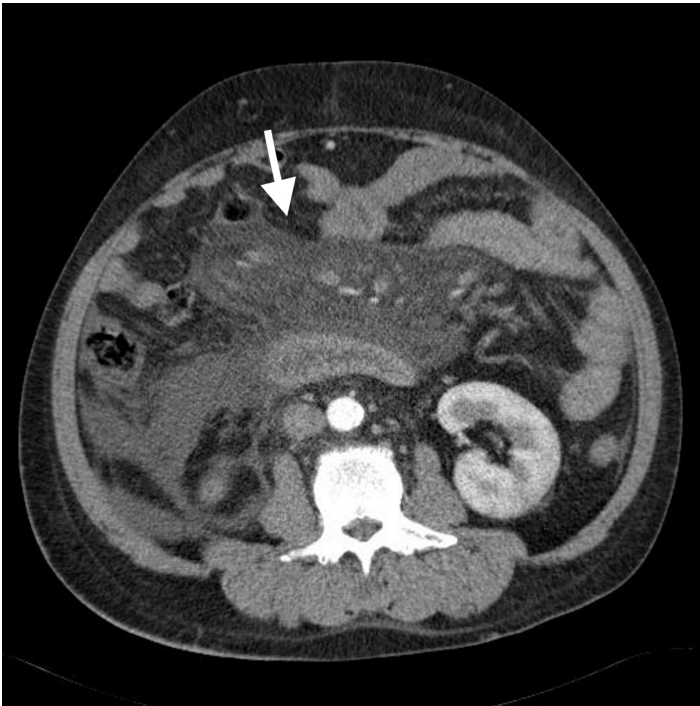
Computed tomography showing “misty mesentery” fat stranding (arrow) surrounding mesenteric vessels with ascites
